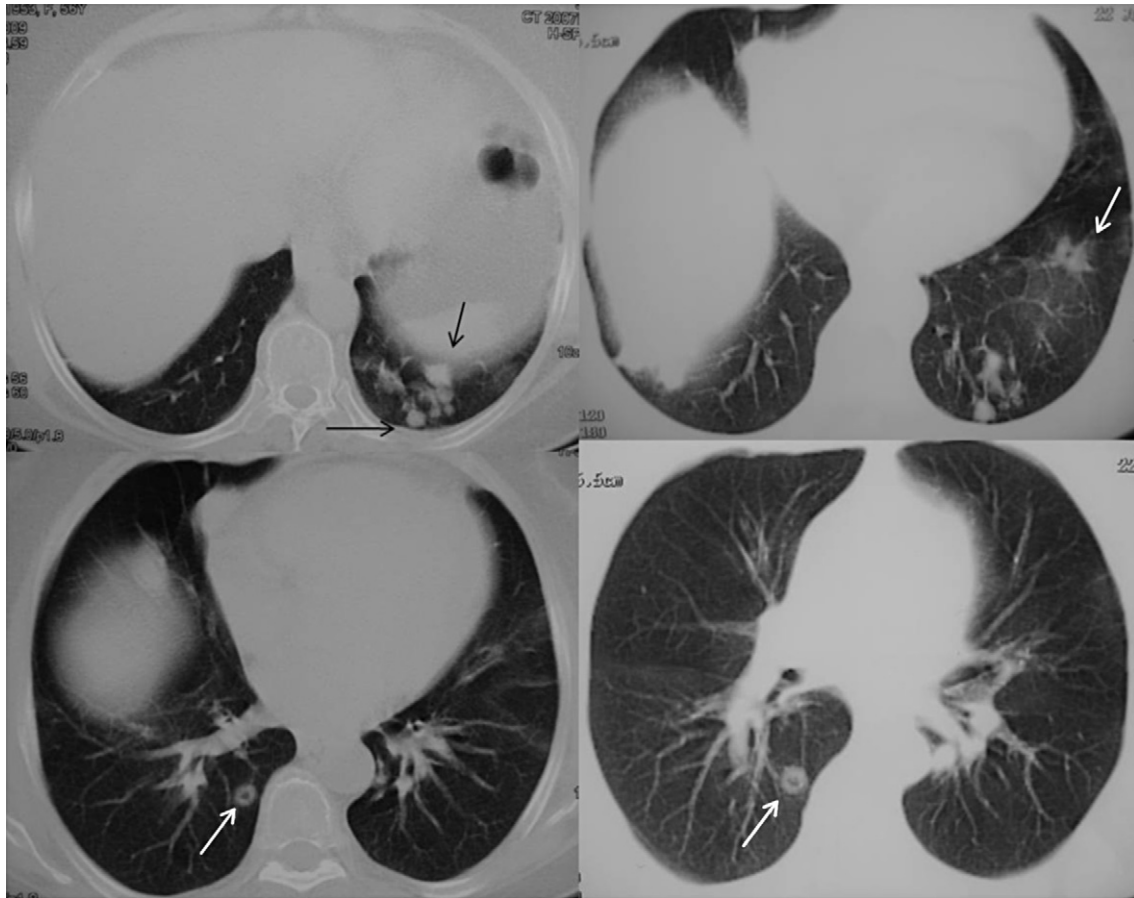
(Patient 3): The fifty six years old Turkish women was admitted to the hospital with cough and fever. Unlike the first and second patients, she did not have any history of diseases, before. Firstly, she was treated as pneumonia with levofloxacin, but she did not improve. After performed thorax CT, the result of thorax CT revealed the bilateral necrobiotic and nodular lesions which some of them were cavitate. When we listened the detailed medical history from her, she was suffering from arthritic symptoms and she had a story of rheumatoid skin lesion on the olecranon. Her rheumatoid factor was 467 IU/ml in the serum. We think the pulmonary involvement of rheumatoid arthritis according to the clinical, radiological and laboratory findings. After immunosuppressive treatment, her symptoms were improved. As a results, the nodular lesions in this our third patient's lung were the first signs of rheumatoid arthritis.
